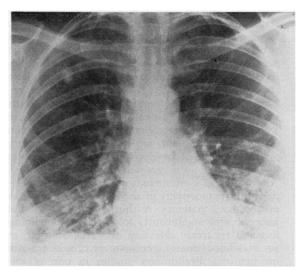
Case 2. Chest radiograph showing diffuse interstitial infiltration.
